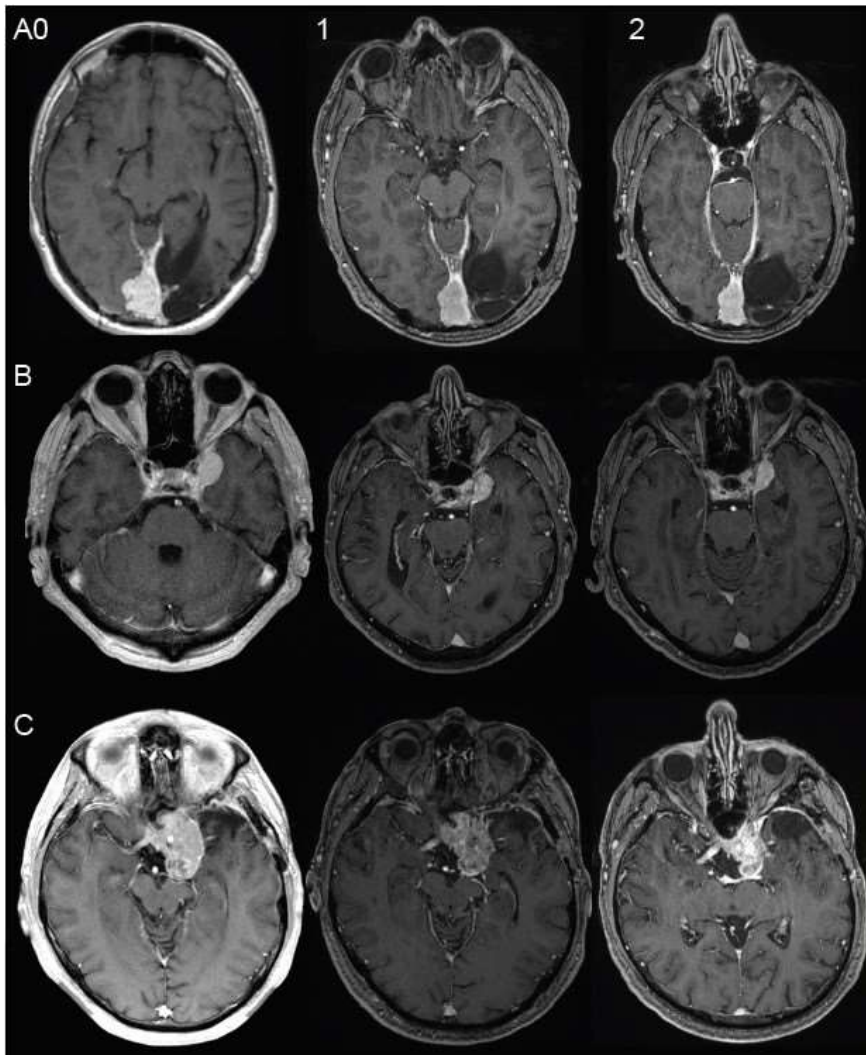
(0) Baseline MRI (for treatment planning) and follow-up MRIs after one (1) and two years (2) after RT by photons (A), protons (B) and after a combined RT by photons and carbon ions according to the MARCIE-protocol (C).
